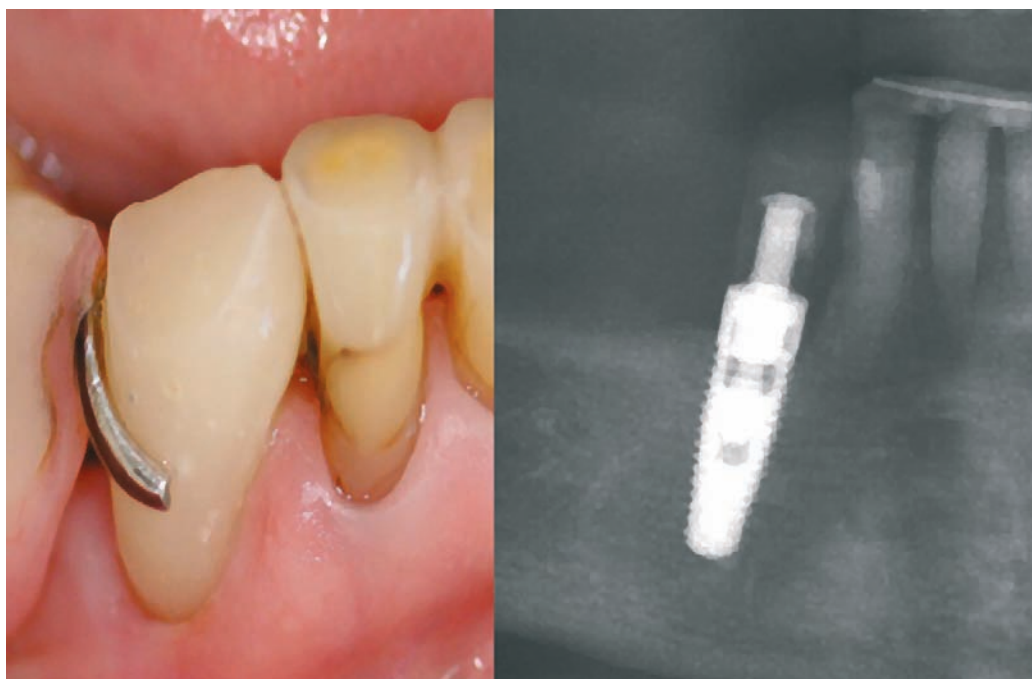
Immediate implant provisionalization fitting an existing RPD after three months of clinical use. b) Radiographic control.
